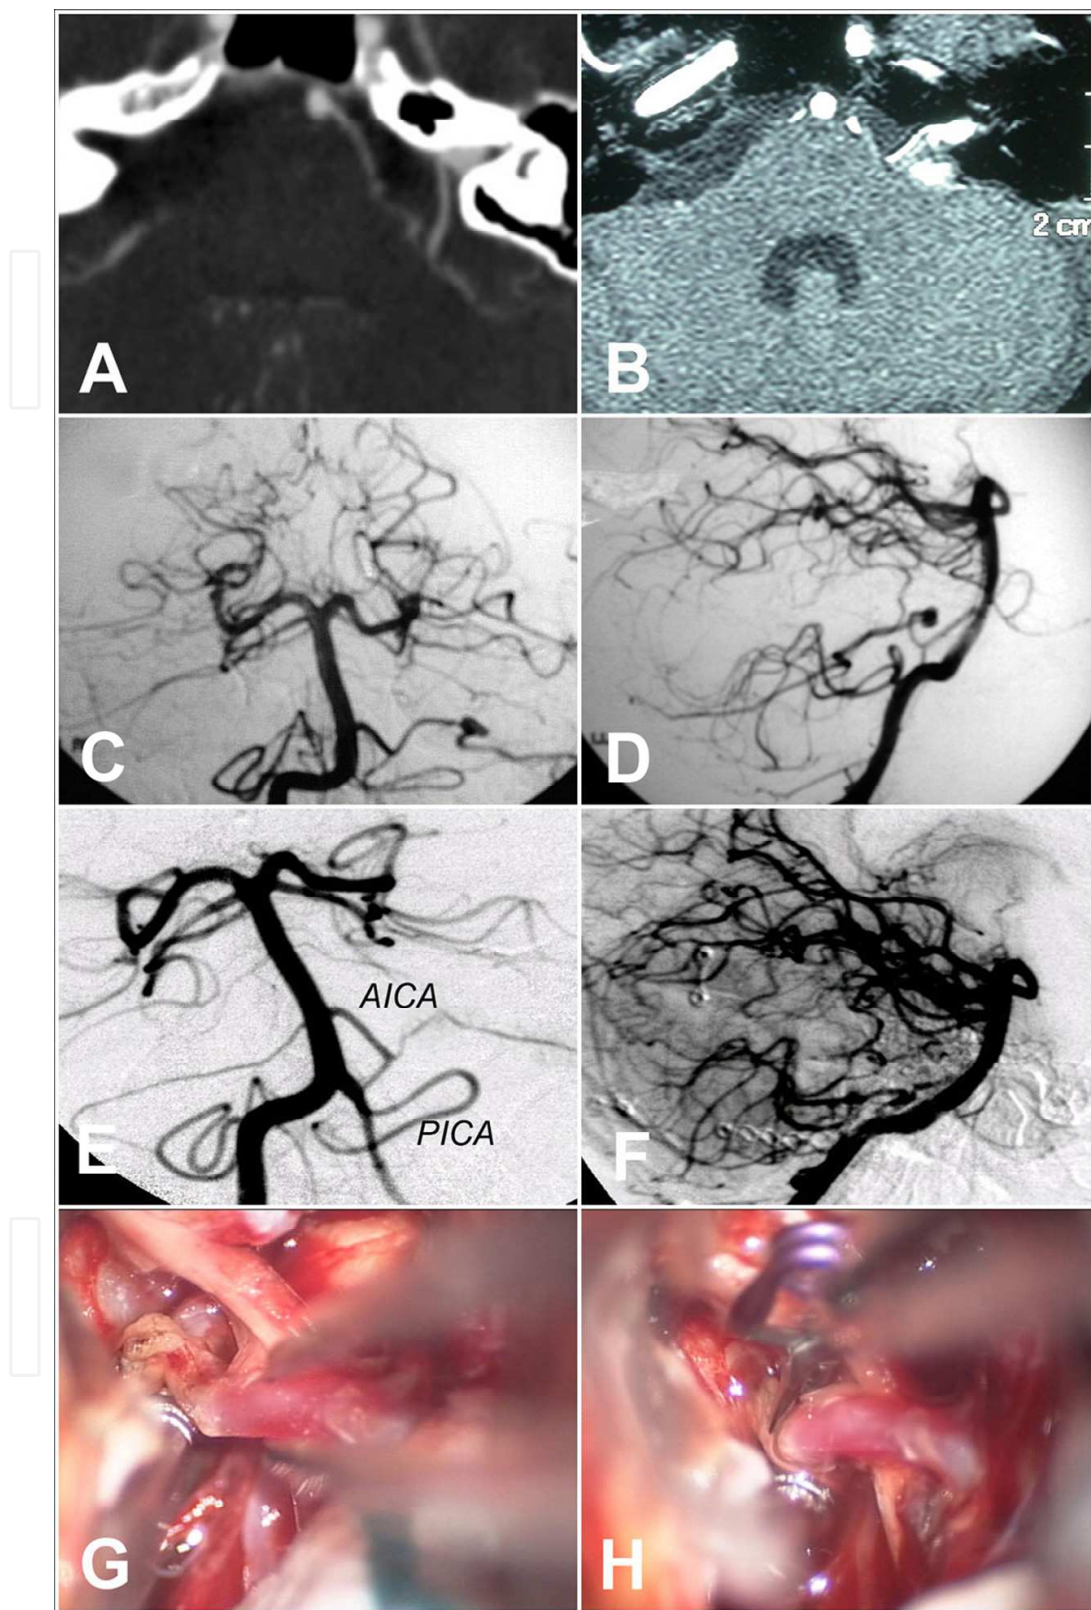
Preoperative angio-CT (A), preoperative MRI (B), preoperative angiography (C,D), postoperative angiography (E,F) and intraoperative images of a distal AICA aneurysm, located intrameatally, which was treated through a left retrosigmoid approach; exposure of the aneurysmal sac required drilling of the posterior wall of the internal acoustic meatus.
